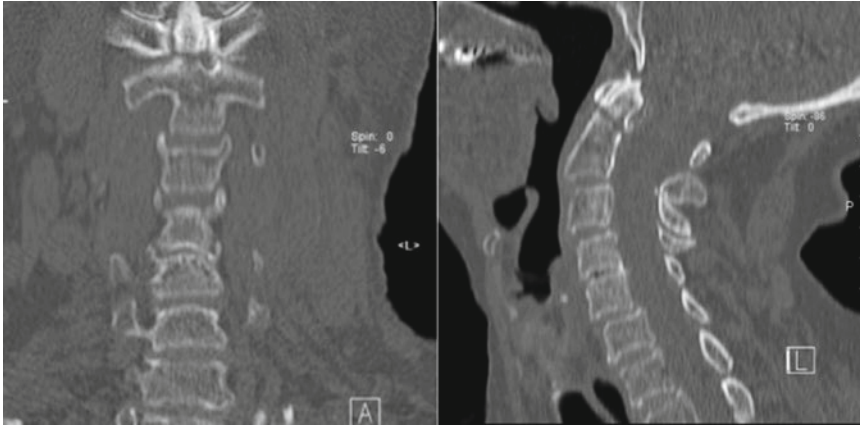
Preoperative coronal (*left*) and sagittal (*right*) CT imaging showing an acute type II odontoid fracture
